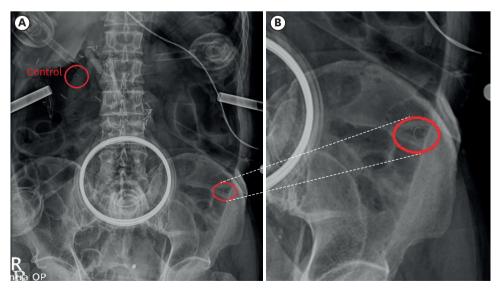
Lost needle shadow on plain abdominal radiographic examination. The control needle's shadowing is visible in the right upper quadrant (red circle) and the lost needle's in the left lower quadrant (red circle) (A). Magnified view of the lost needle (B).
